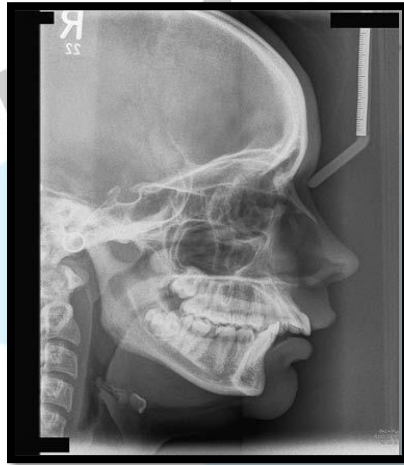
A lateral cephalometric radiograph. An aluminium wedge has been positioned to attenuate the beam thereby enhancing the view of the soft tissues.
